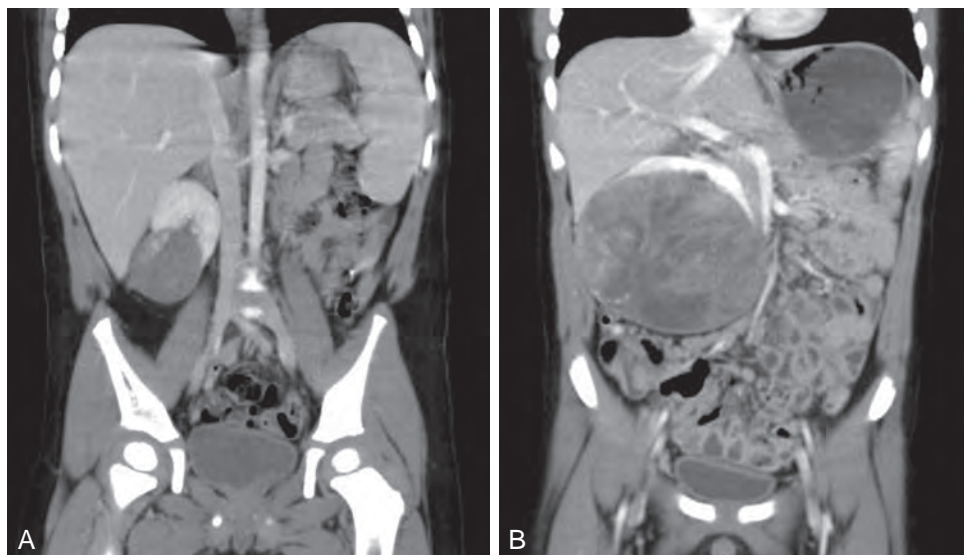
A, Computed tomography scan of a Wilms tumor that was pretreated with chemotherapy. B, After 6 weeks of chemotherapy, the tumor is much smaller.
